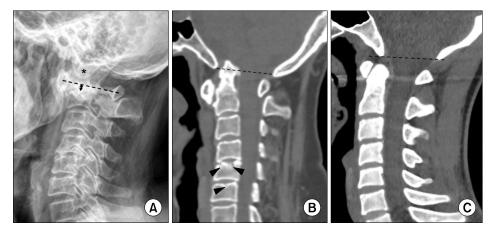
(A) Three years later, the Ranawat $C1 \sim C2$ index (double-headed arrow) is markedly decreased, suggesting basilar impression. Note the odontoid process (asterisk) is protruded beyond the horizontal axis of atlas (dashed line). (B) The reformatted sagittal computed tomography (CT) scan shows that the odontoid process is protruded above the level of foramen magnum (McRae line; dashed line). There are multiple erosions (arrows) in the C4, C5 discovertebral area. (C) A reformatted sagittal CT scan of a 25-year-old healthy female. The odontoid process is under the McRae line (dashed line).
